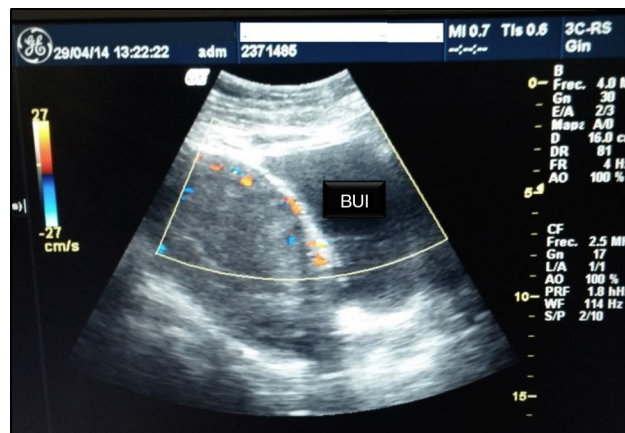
Doppler ultrasound scan. BUI: bladder and uterine interface.
